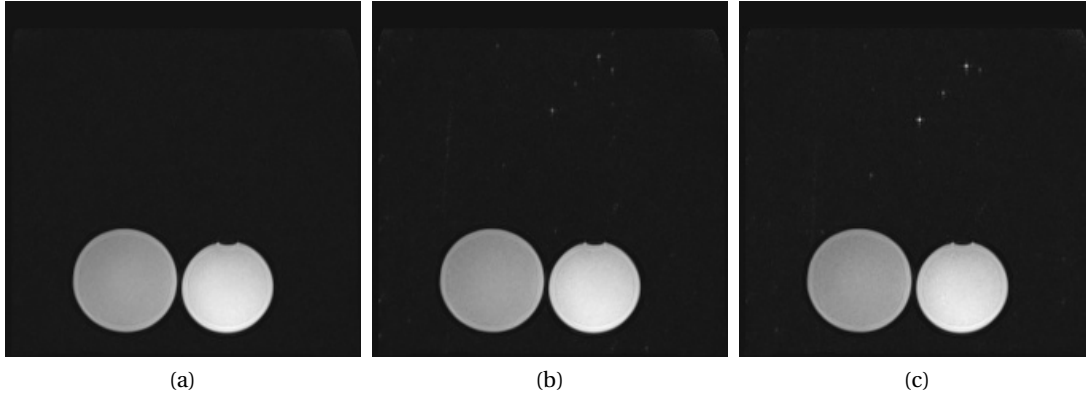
Evaluation of MR image artifacts due to operation of the RGB-D sensor inside the MRI room. MR images for three scenarios are depicted: First, no active device is inside the MRI room (a). Second, the USB extension cable is passed through the waveguide of the MRI room with no devices connected at its ends (b). Third, RGB-D sensor and external PC are connected via USB through the waveguide and turned on (c). The image artifacts in (b) and (c) are similar but slightly more intense for (c) where the RGB-D sensor is active.
